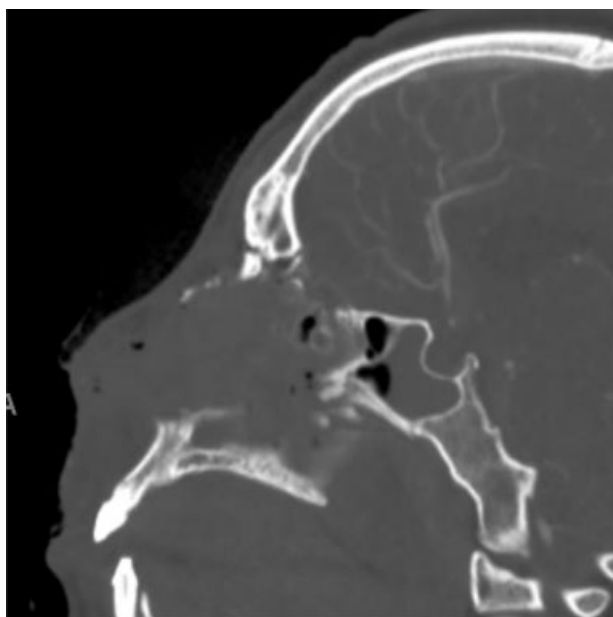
High-resolution sagittal CT in trauma patient shows defect along posterior wall of frontal sinus which manifested as CSF rhinorrhea. CT, computed tomography; CSF, cerebrospinal fluid.
